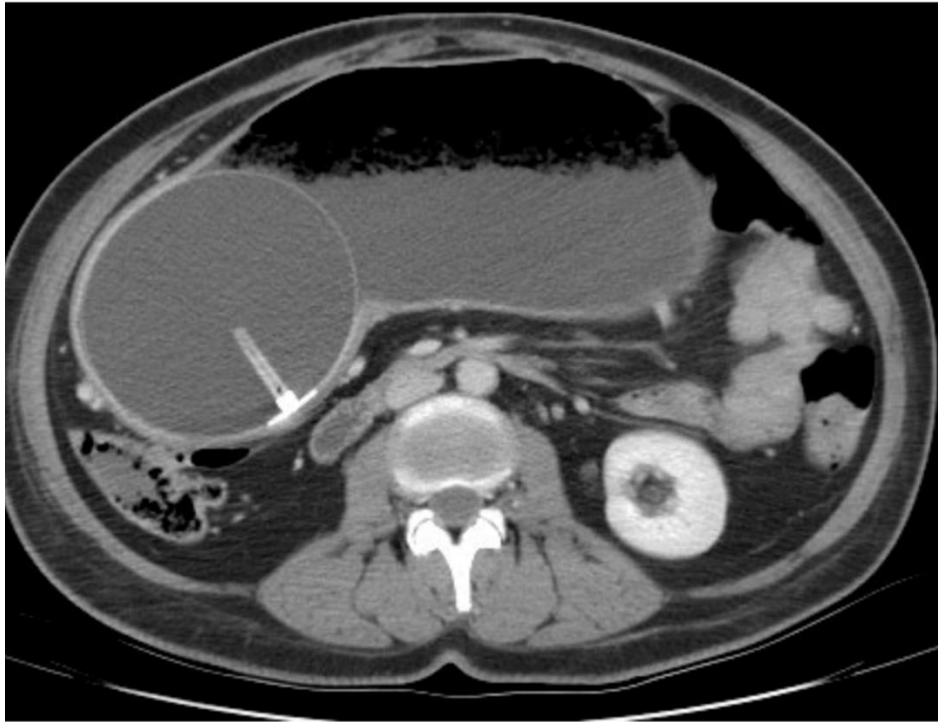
CT Image showing intra gastric balloon causing obstruction
